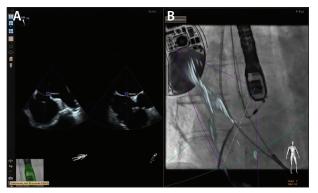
A fiducial marker ("Marker 1") is placed over an appropriate location on x-plane transesophageal images (A), and the same translates to a corresponding location on anteroposterior fluoroscopic imaging (B) to guide TSP.
